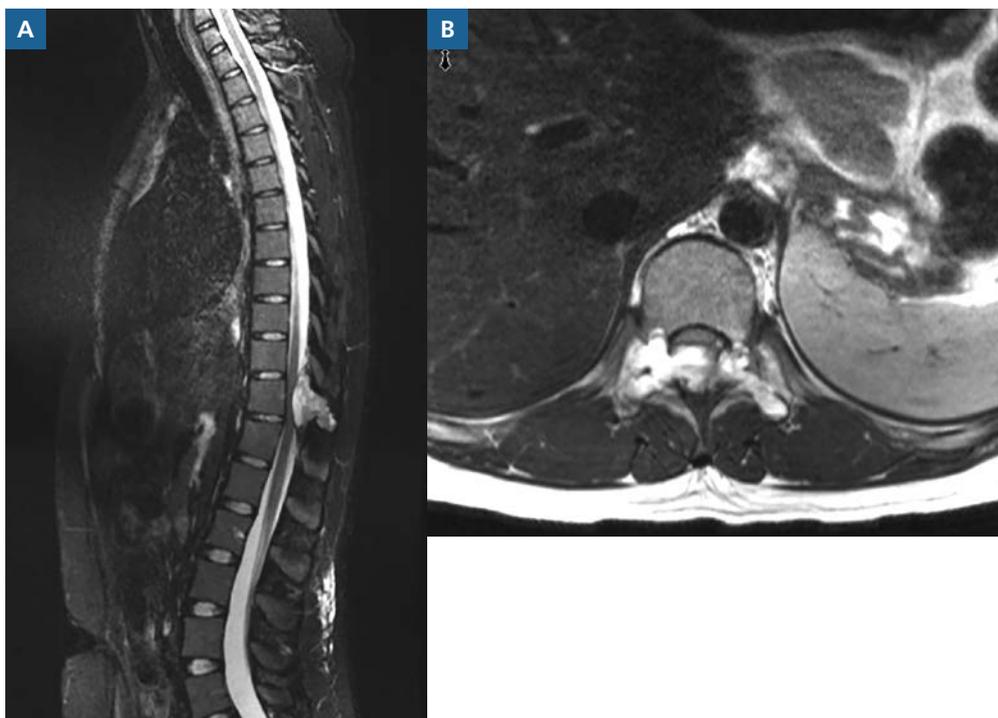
Preoperative A, sagittal and B, axial MRI. A multilobulated cyst enhances the lesion that involves spinous process, lamina, pedicles and posterior aspect of the vertebral body of T11. There is a narrow zone of transition without marrow edema. Multiple fluid-fluid levels are present within this multicystic lesion. There is compression of the cord by high grade stenosis but no abnormal signals within the cord. The remainder of the thoracic spine and surrounding soft tissues are normal and show no infiltration.
